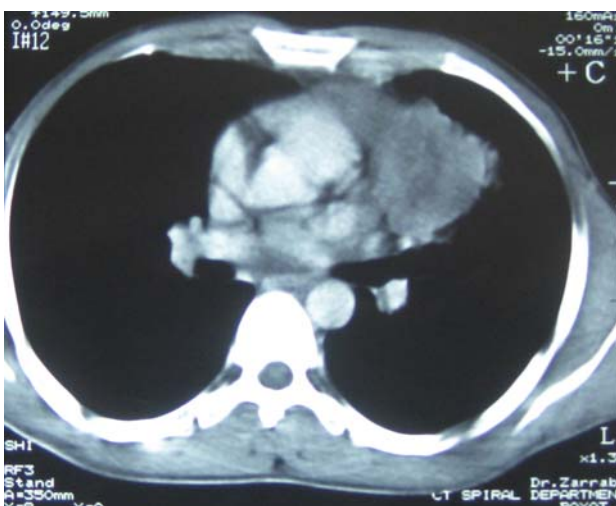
Spiral CT-Scan with contrast showed anterior mediastinal mass.
